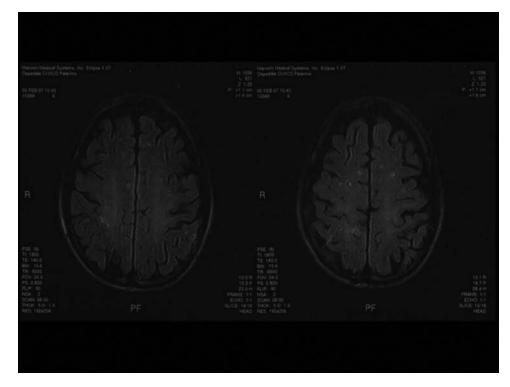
Brain MRI with intravenous contrast, showing multiple periventricular and subcortical hyperintense lesions.
